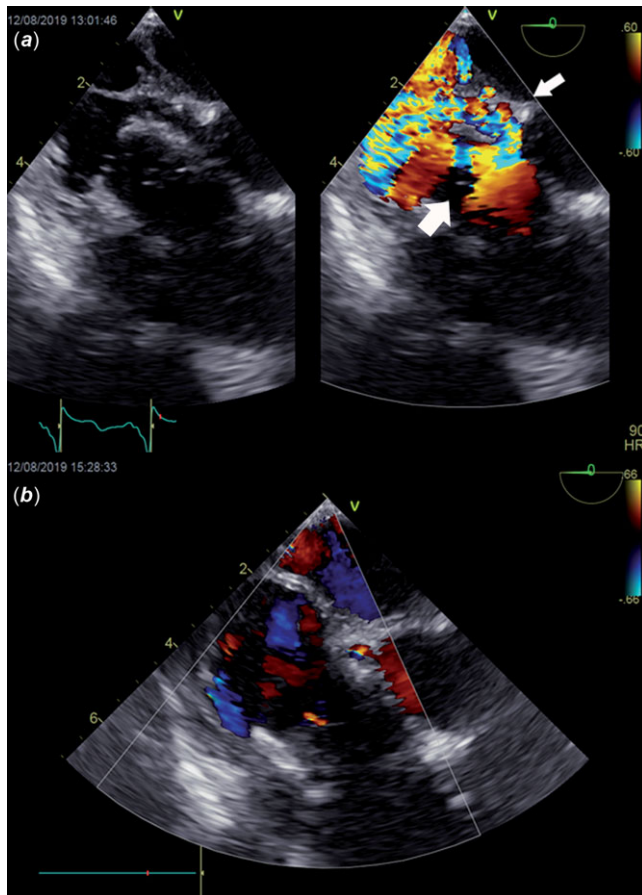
(a) Simultaneous 2D and colour transoesophageal echocardiography, 0 degrees view: tricuspid valve with severe regurgitation (wide white arrow) and significant paravalvular leak (narrow white arrow). (b) Colour transoesophageal echocardiography, 0 degrees view: traces of tricuspid regurgitation and closure of paravalvular leak.
